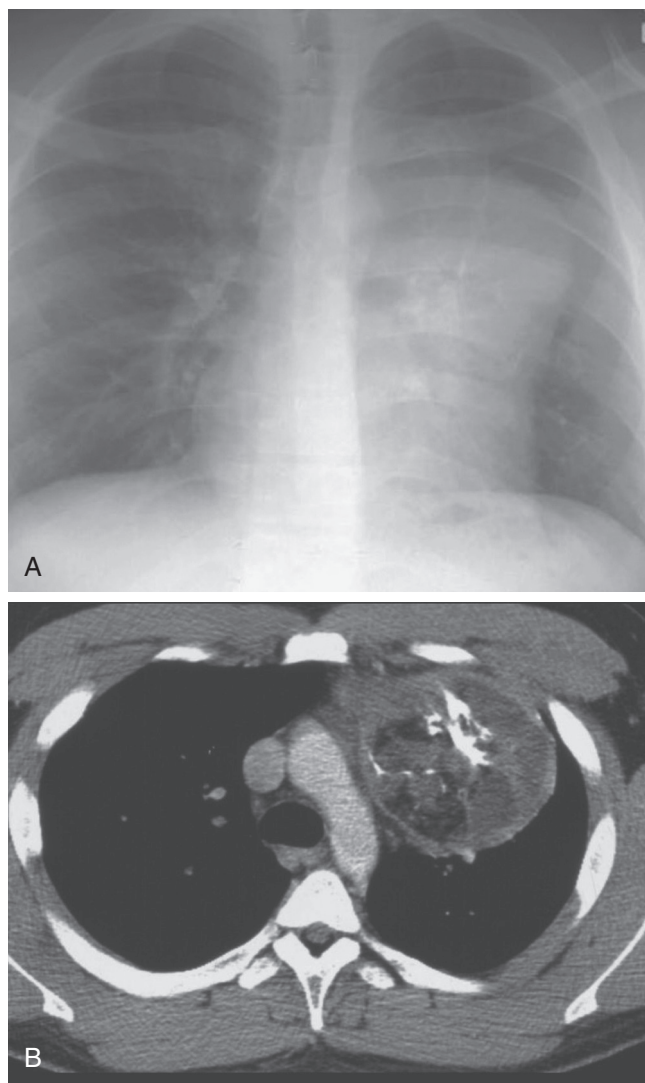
■ Anterior mediastinal mass. A, Posteroanterior chest radiograph demonstrates a smoothly margined, left-sided anterior mediastinal mass. B, Axial computed tomographic image confirms the mass, with mixed heterogeneous components, including fat, soft tissue, fluid, and calcification. These findings are diagnostic of a teratoma.
